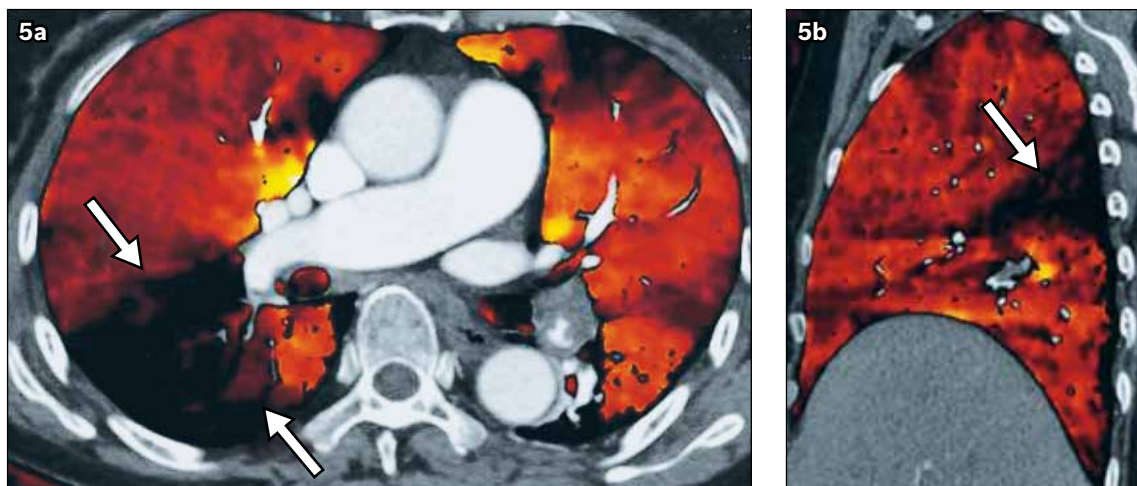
(a) Axial and (b) sagittal vascular iodine distribution maps (a recent innovation of dual-energy CT for showing lung perfusion) in a 69-year-old woman who presented with chest pain that was worse on exertion. These images are colour-coded as per choice, and a characteristic dark wedge-shaped defect (arrows) due to pulmonary embolism is seen in the apical segment of the right lower lobe. The rest of the lung shows normal perfusion.
